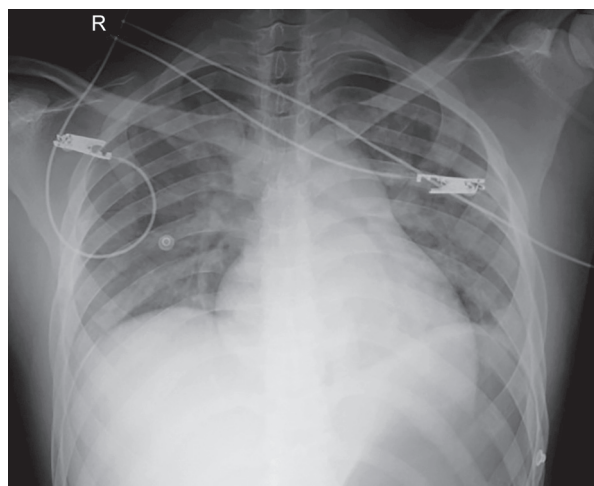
Thorax radiograph on the day of admission
